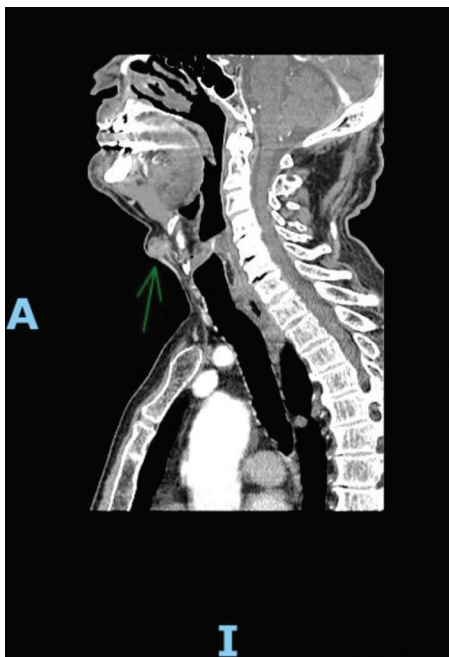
Sagittal computed tomography scan showing the thyroglossal cyst, a solid-cystic tumor lesion of the anterior cervical soft tissues of an altered malignant neoplastic nature.
